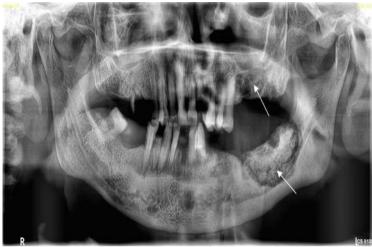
Panoramic Radiograph Reveals Mixed Radiopaque and Radiolucent Lesion on Left Body of Mandible Involving the Inferior Alveolar Nerve and Ill Defined Radiolucency Noted in Left Maxilla Extending from 24 to 26 Region
